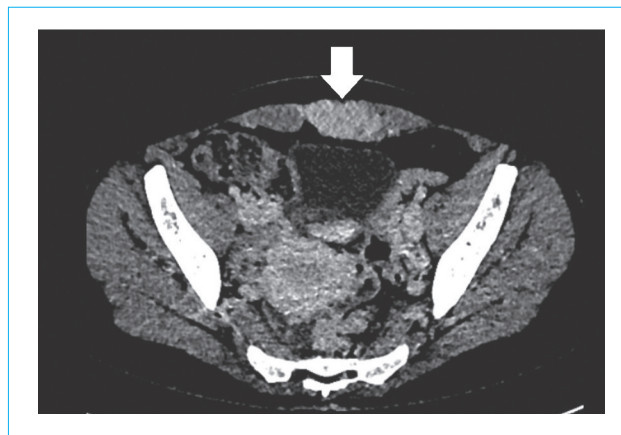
Abdominal contrast-enhanced computed tomography (delayed phase) of a 38-year-old patient with complaints of minor pain and discomfort in the periumbilical region on the left. There is solid rounded well-circumscribed mass with homogeneous diffuse contrast enhancement in the left rectus muscle. According to the results of fine needle biopsy, a desmoid tumor (data obtained by the authors of the article)
